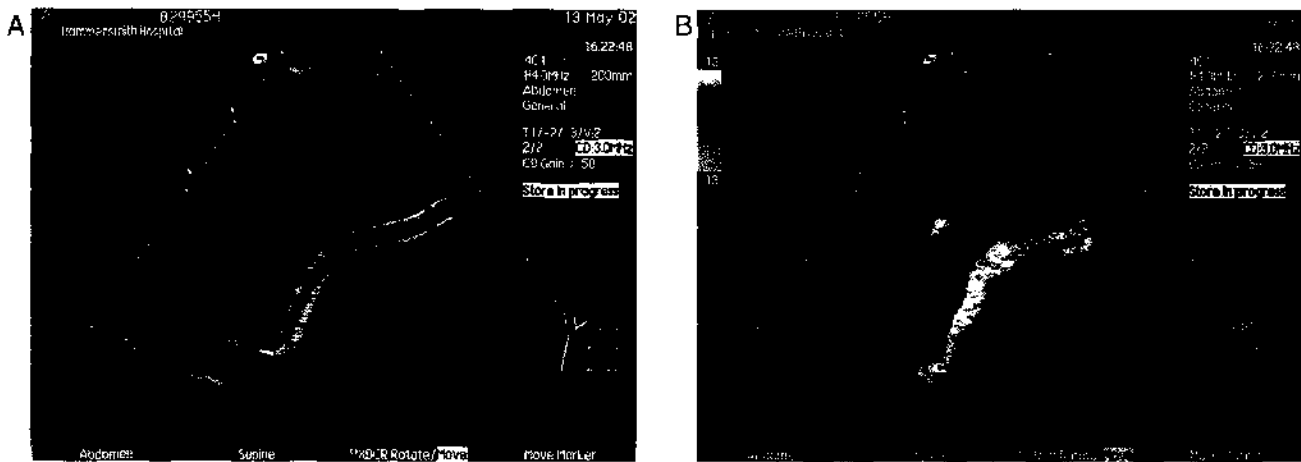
This long transjugular intrahepatic portosystemic shunt is well visualized (A) and the flow is clearly seen to be toward the hepatic vein on the Doppler study (B). (See Plate 4.)
